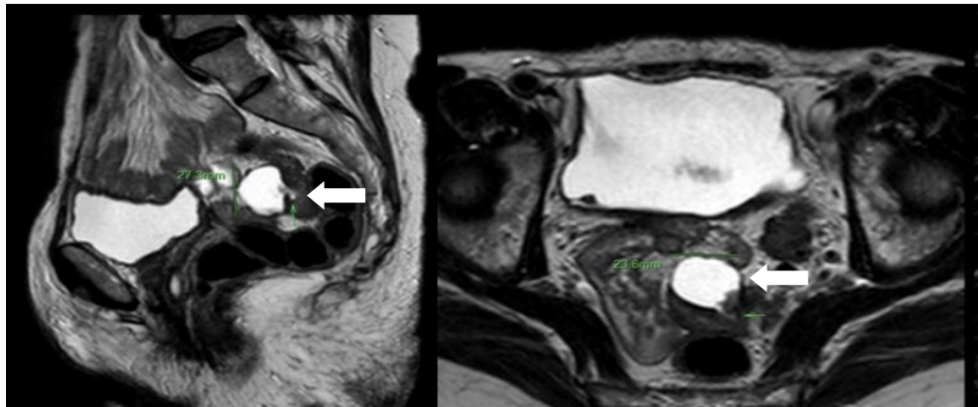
Case 1. The magnetic resonance imaging reveals a multilobulated lesion in the sigmoid colon, exhibiting hyperintensity on T2 and cystic or mucinous characteristics. An eccentric hypermetabolic solid area is identified, suggesting a peritoneal implantation secondary to a history of ovarian cancer (arrow).
